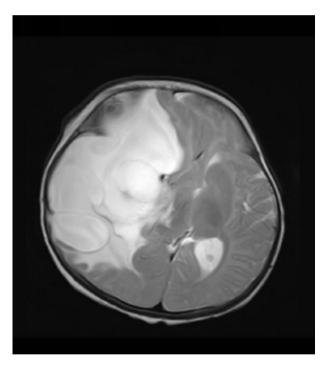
Sample brain MRI Image
